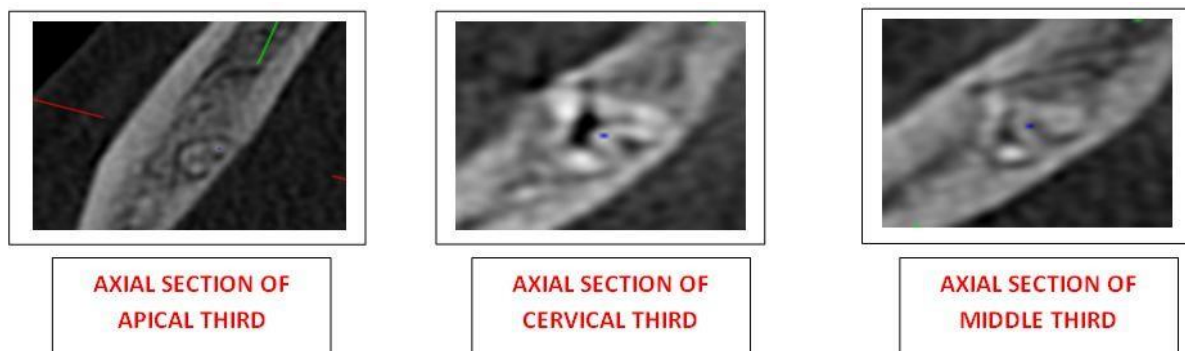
CBCT Axial Sections of apical, cervical & middle third
